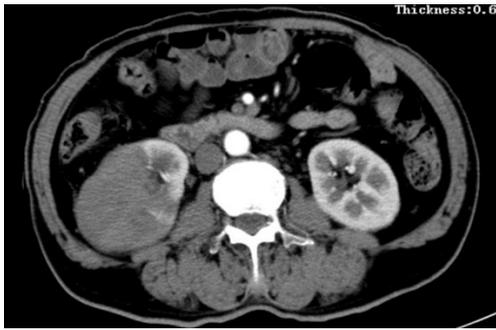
A contrast-enhanced CT finding at the disease onset shows a huge mass (8.5×6.8 cm in diameter) of the right kidney.
